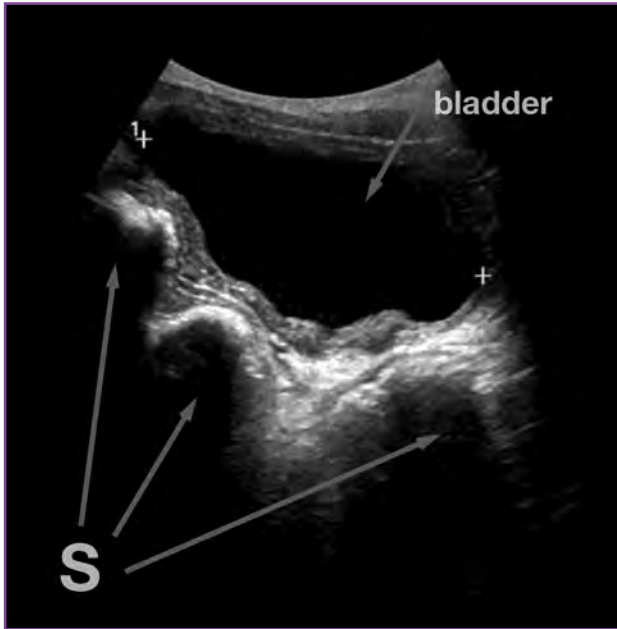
Large stool balls posterior to the bladder are denoted by the S seen in the rectum and are distorting the shape of the bladder. These are prominent and visible at pelvic ultrasonography.
